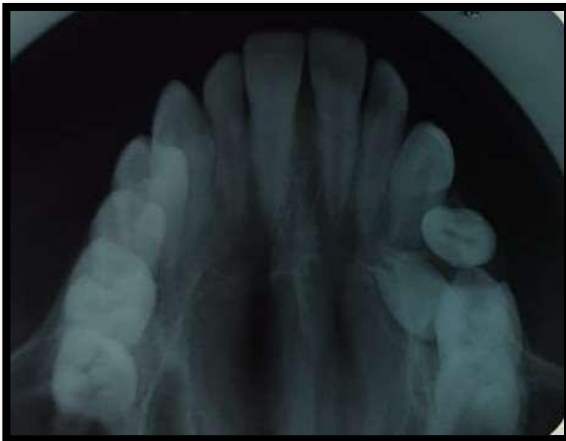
Maxillary Occlusal radiograph
